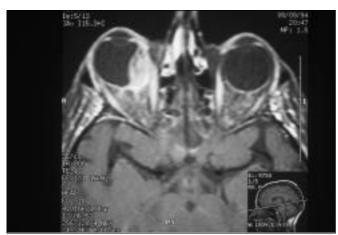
Magnetic resonance imaging reveals a biconvex mass involving the medial wall of the right eye.
